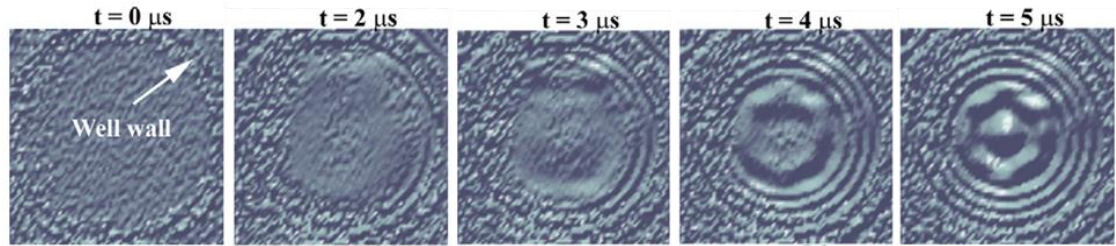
Laser Doppler Vibrometer scans of well base during ultrasonic stimulus. adapted from [58]. Frequency was 1.035 MHz and the transducer was immersed in a water tank with the front face positioned 7 mm below the culture well. The images clearly show the plate vibrations induced by LIPUS exposure.
